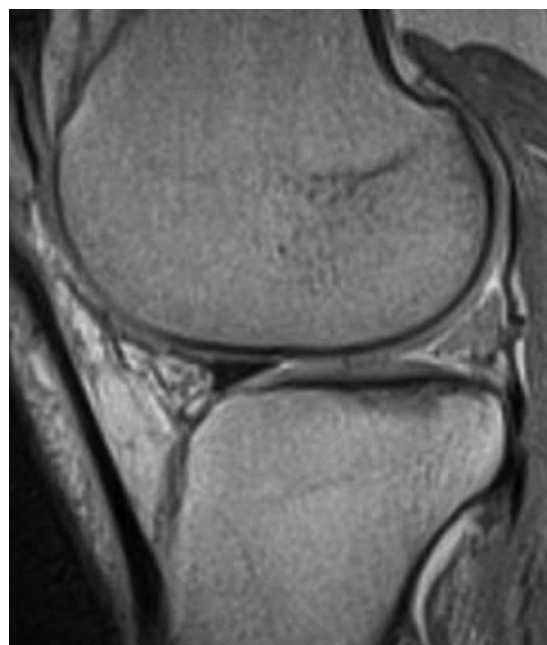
Sagittal T1-weighted spin-echo MRI at 1.5T after 1 year. The size of the implant in this case is the same as the normal meniscus (type 3). Signal intensity remains increased (type 1).
